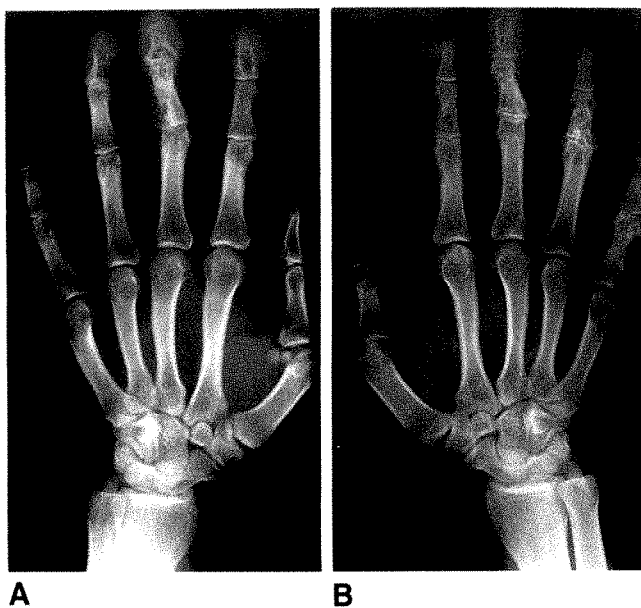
Case 2: 26-year-old black man with 2-year history of intermittent swelling and tenderness of hands. A and B, Radiographs of left (A) and right (B) hands.
